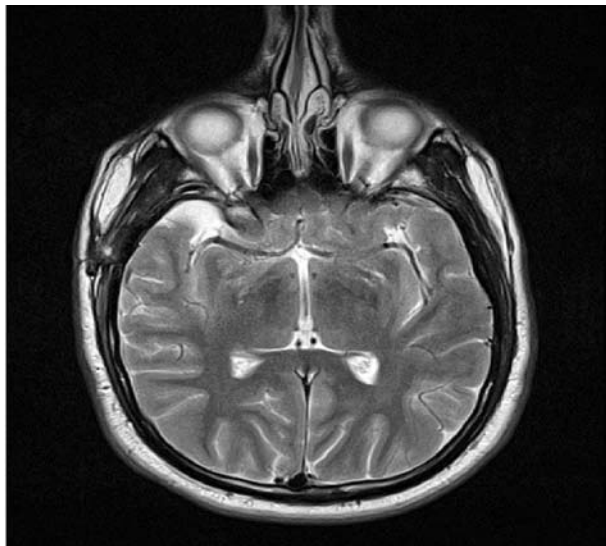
Postoperative native axial MR T2-weighted image showing almost complete shrinkage of the arachnoid cyst.
